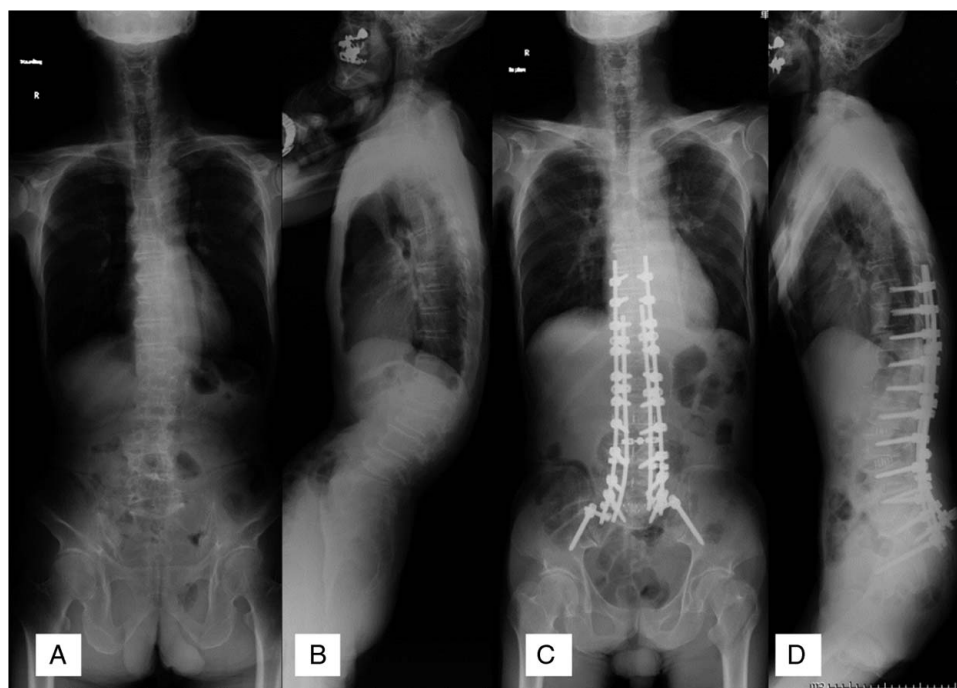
A 71-year-old male patient with spinal kyphosis. Left ventricular ejection fraction changed from 52% to 69%, and inflection point level changed from L4 to L1 postoperatively. Whole spine radiographs were performed in the standing position (A, B) preoperatively and in the supine position (C, D) postoperatively.
